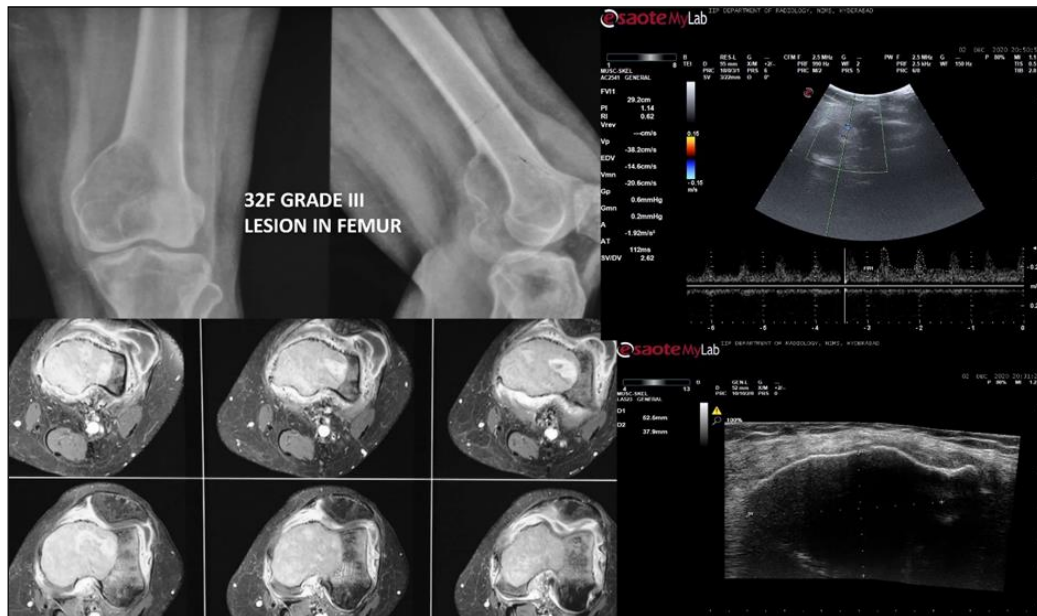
32/F Contrast enhanced MRI in axial plane shows heterogenous enhancement. Lesion is heteroechoic with low RI on colour doppler USG
